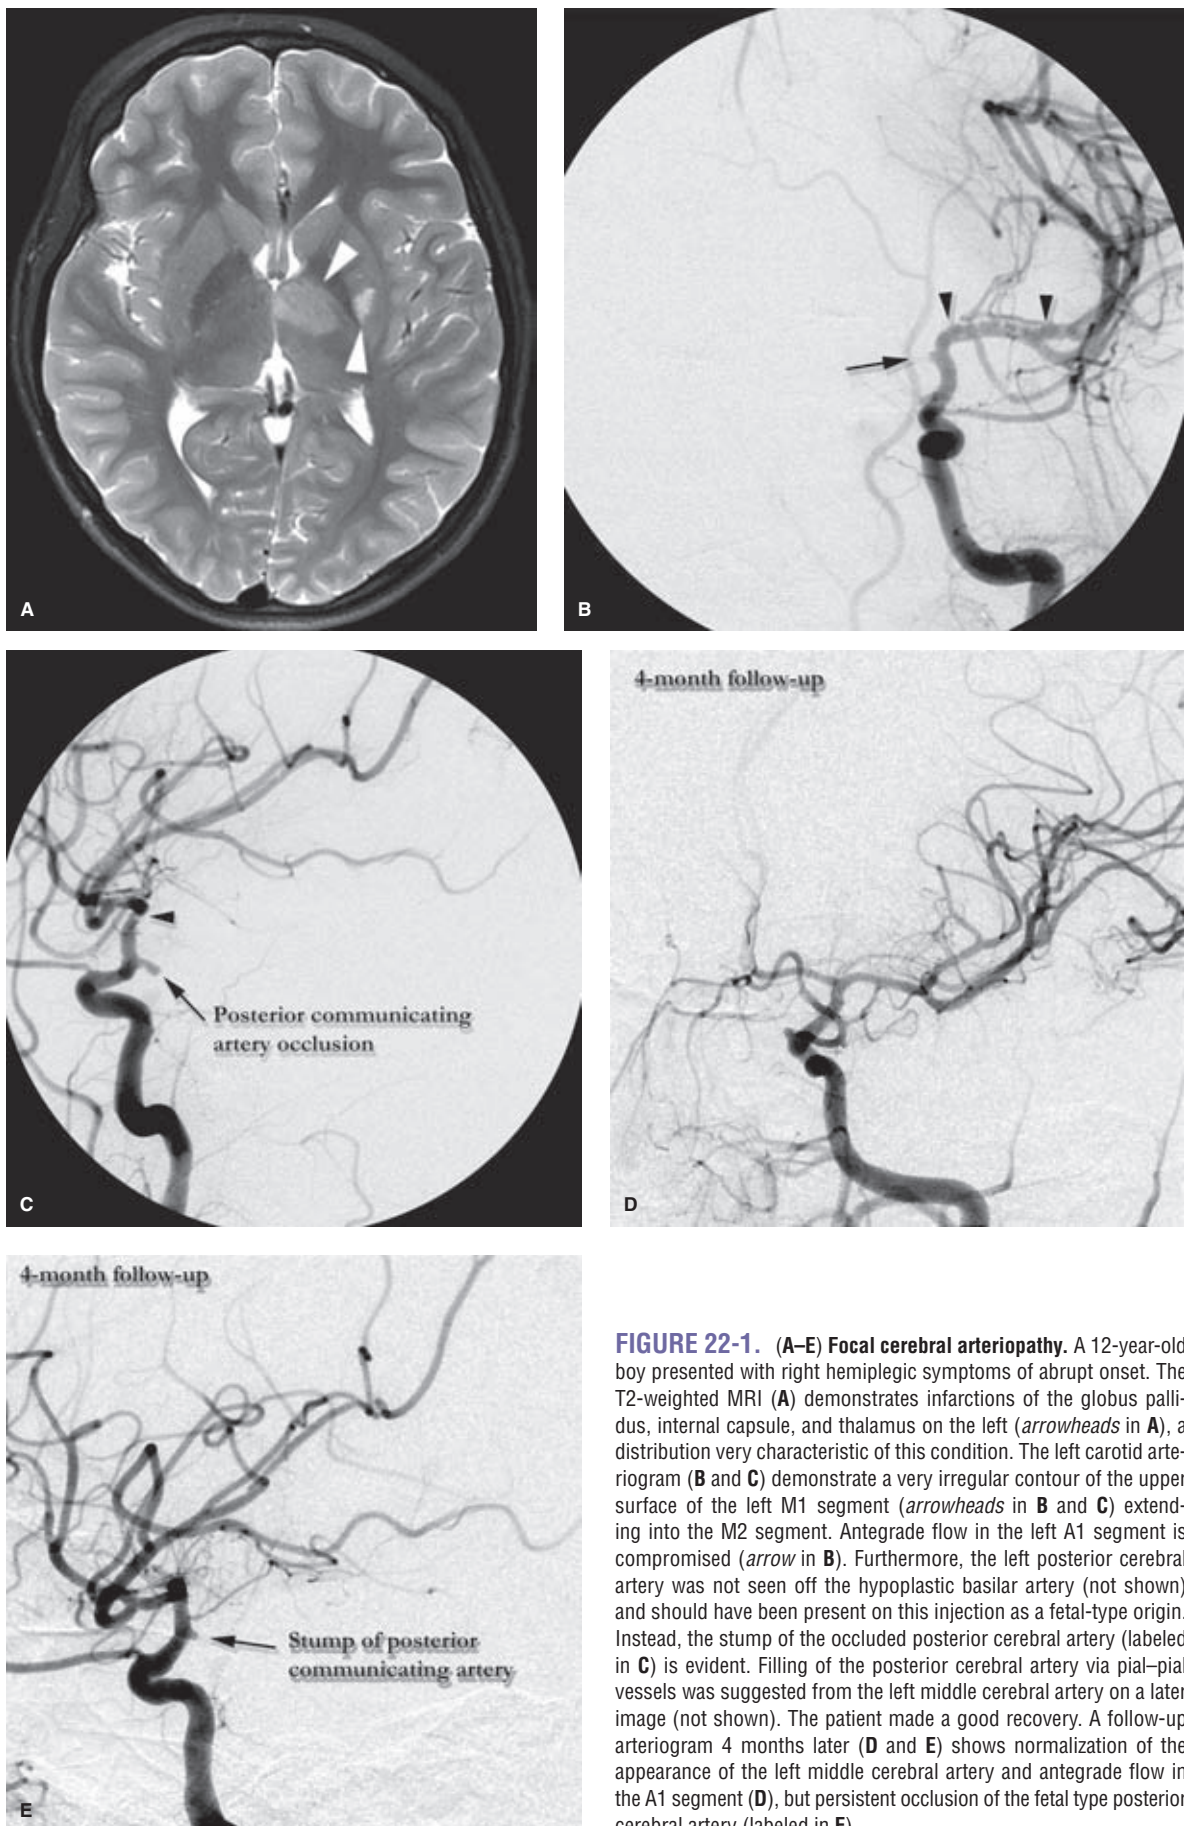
(A–E) Focal cerebral arteriopathy. A 12-year-old boy presented with right hemiplegic symptoms of abrupt onset. The T2-weighted MRI (A) demonstrates infarctions of the globus pallidus, internal capsule, and thalamus on the left (*arrowheads* in A), a distribution very characteristic of this condition. The left carotid arteriogram (B and C) demonstrate a very irregular contour of the upper surface of the left M1 segment (*arrowheads* in B and C) extending into the M2 segment. Antegrade flow in the left A1 segment is compromised (*arrow* in B). Furthermore, the left posterior cerebral artery was not seen off the hypoplastic basilar artery (not shown) and should have been present on this injection as a fetal-type origin. Instead, the stump of the occluded posterior cerebral artery (labeled in C) is evident. Filling of the posterior cerebral artery via pial–pial vessels was suggested from the left middle cerebral artery on a later image (not shown). The patient made a good recovery. A follow-up arteriogram 4 months later (D and E) shows normalization of the appearance of the left middle cerebral artery and antegrade flow in the A1 segment (D), but persistent occlusion of the fetal type posterior cerebral artery (labeled in E).
